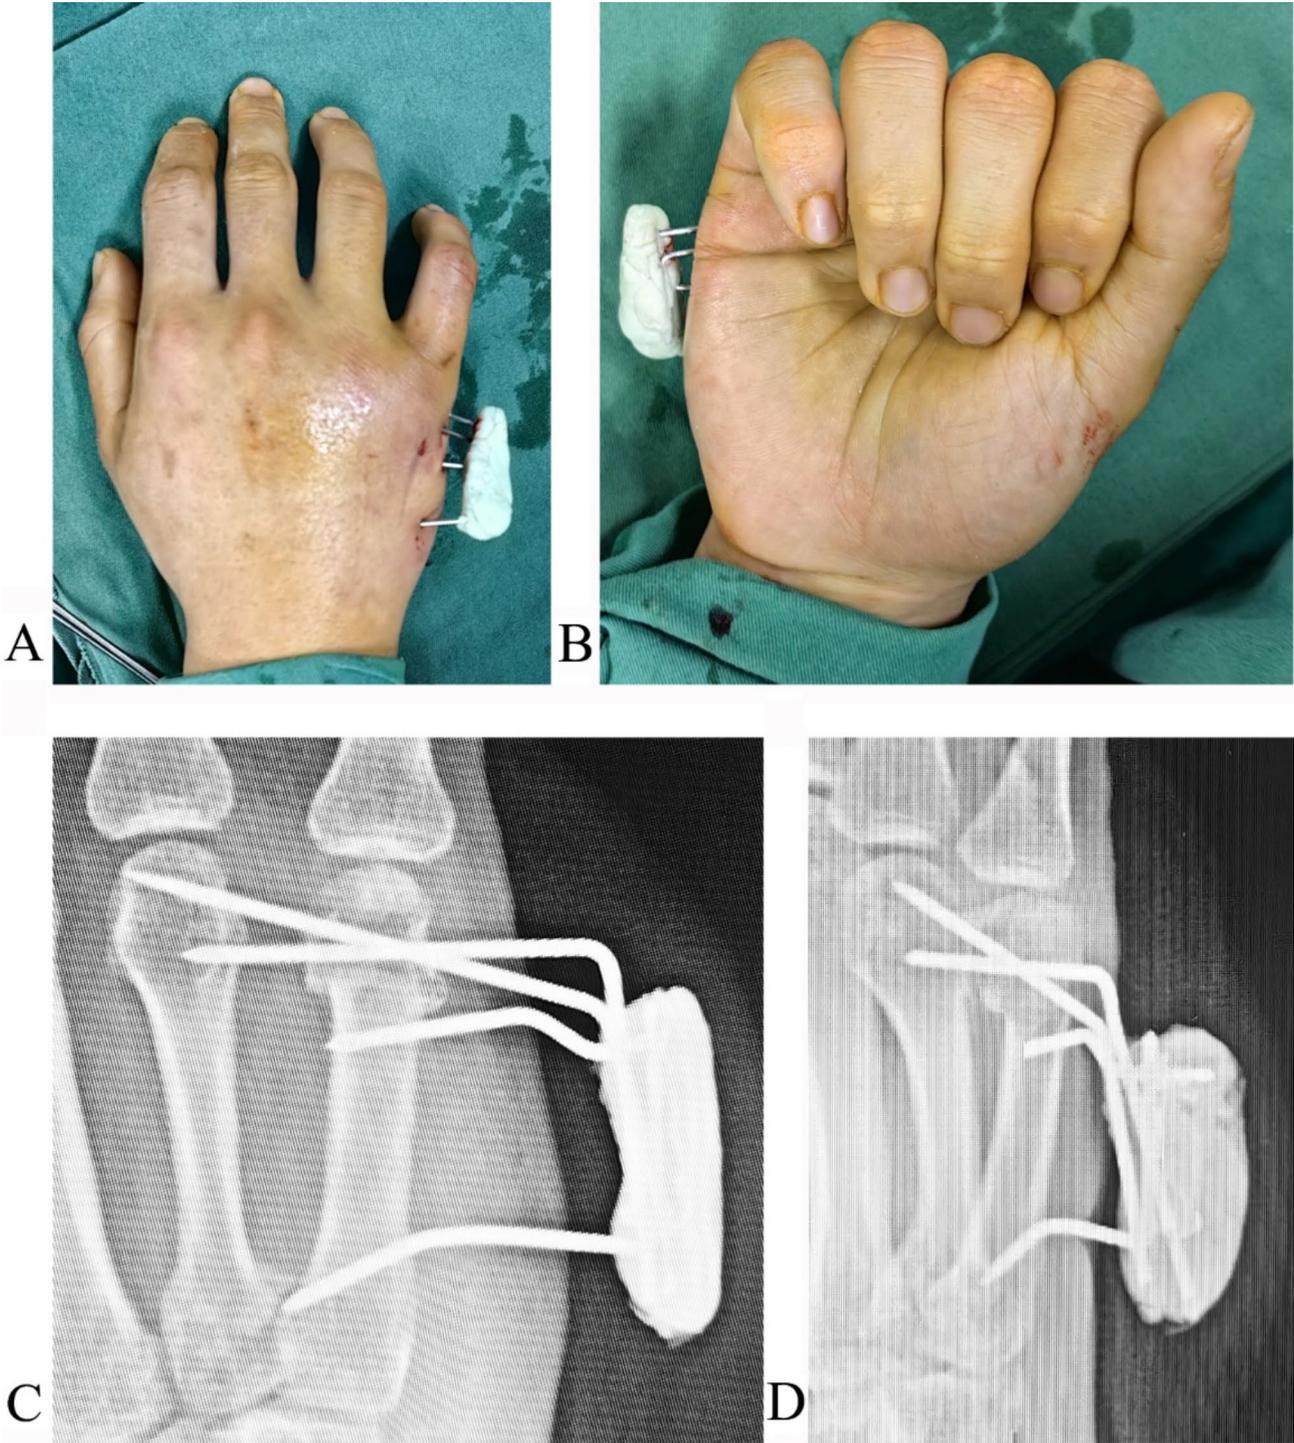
The fracture is fixed with a K-wire and bone-cement frame. A. Dorsal view immediately after surgery. B. Flexion. C. A PA X-ray shows bone healing 1.5 months after surgery. D. Oblique X-ray
